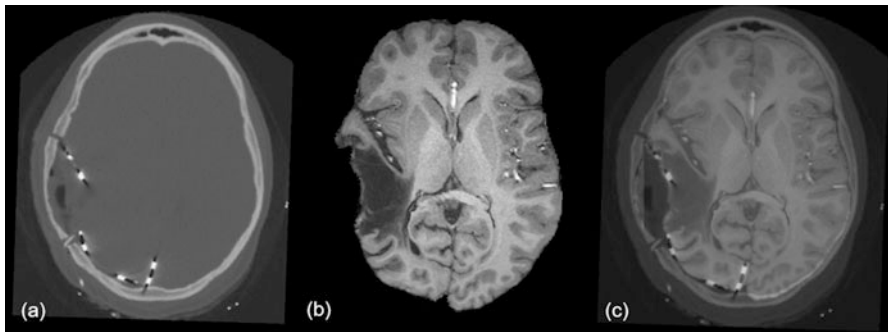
(a) Intra-operative CT; (b) transformed MRI; (c) transformed MRI overlaid on CT
